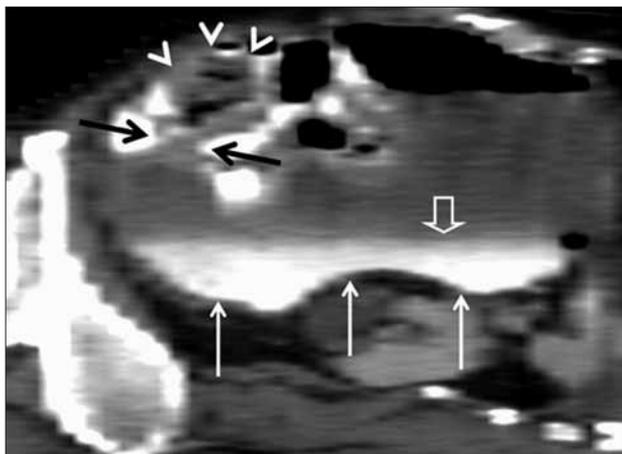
On a parasagittal oblique reformatted CT image, the bezoar formation (*arrowheads*) and the area of perforation (*black arrows*) are demonstrated. The large pouch is also revealed (*white arrows*) with the contrast-fluid level (*open white arrow*).
